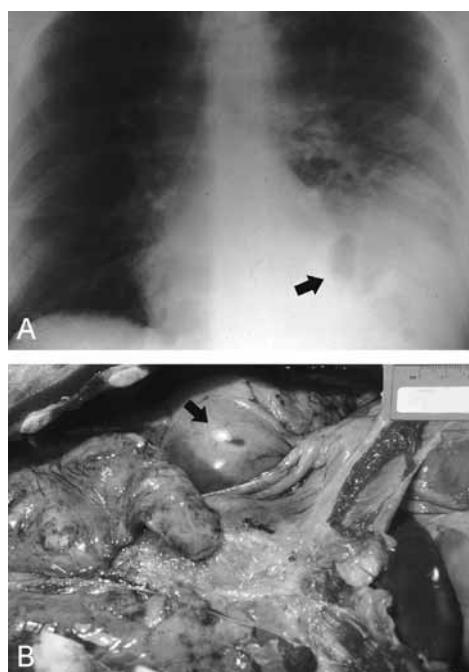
Traumatic rupture of diaphragm. Motor vehicle collisions (two cases). (A) Chest radiograph. Herniation of large bowel. Bowel gas seen (arrow). (B) Another case shows herniation of stomach (arrow) through the torn left hemidiaphragm.
